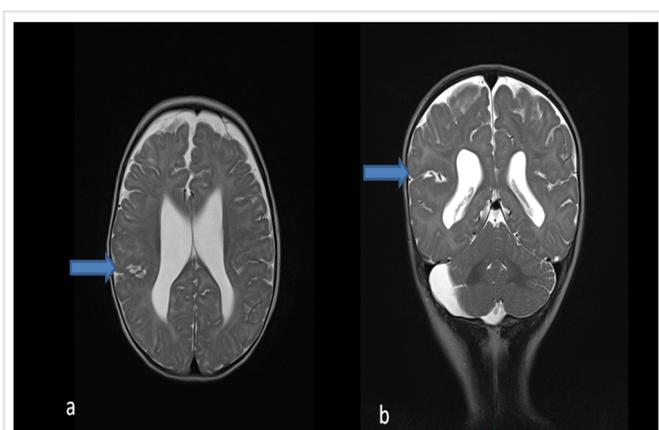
Brain MRI of the girl at 12 months of age. a) axial, T2-weighted -TSE image: opercular right polymicrogyria, mild frontal cortical atrophy. b) coronal, T2-weighted-TSE image: right retrocerebellar cyst and right opercular polymicrogyria.
